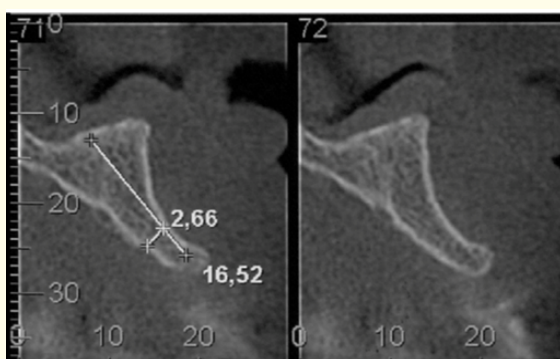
CT scan confirming the need for bone grafting.
